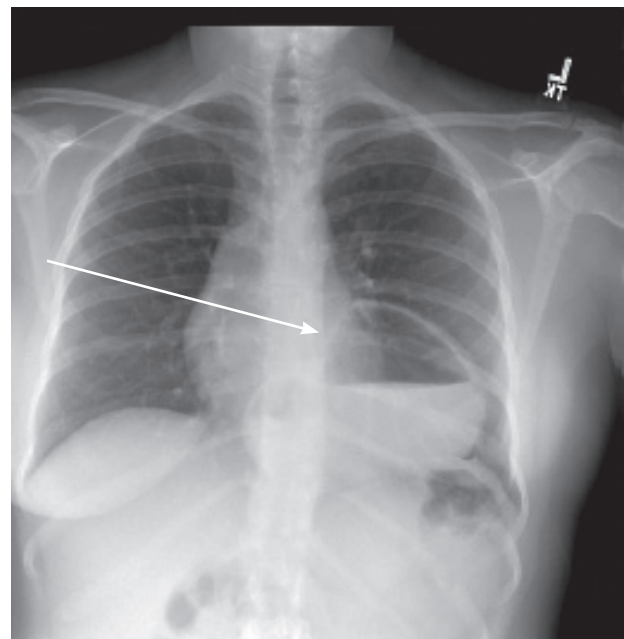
Chest X-ray showing hiatal hernia
